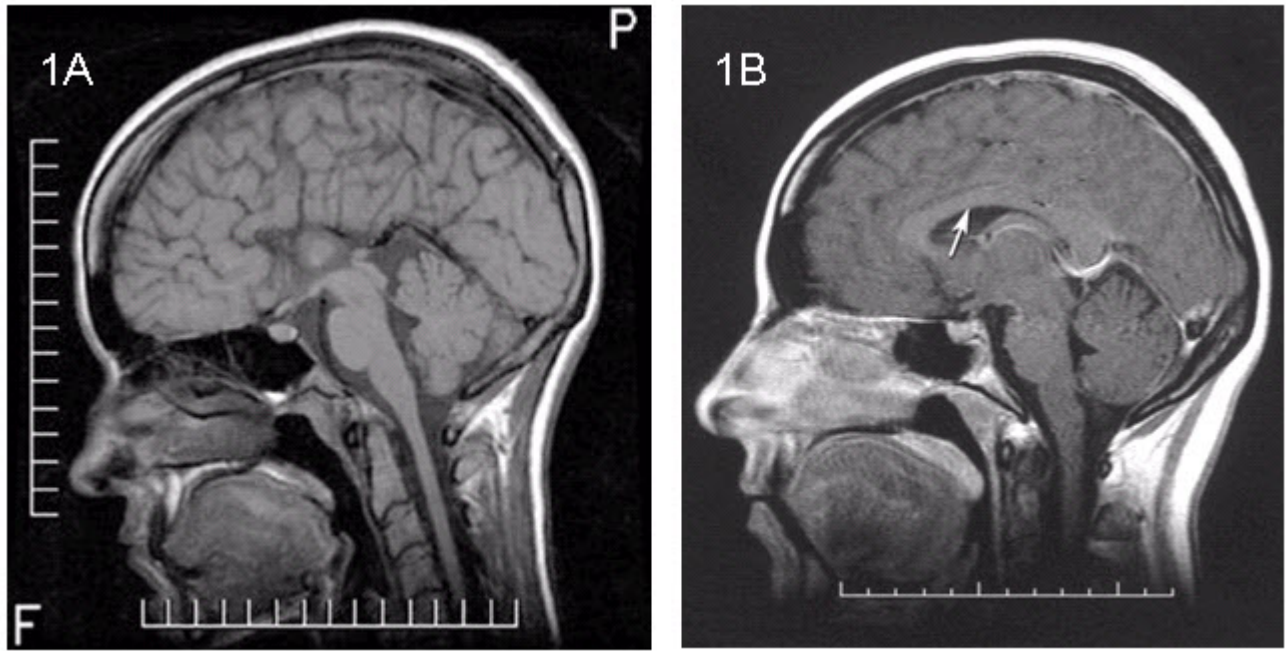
Sagittal T₁-weighted MRI
